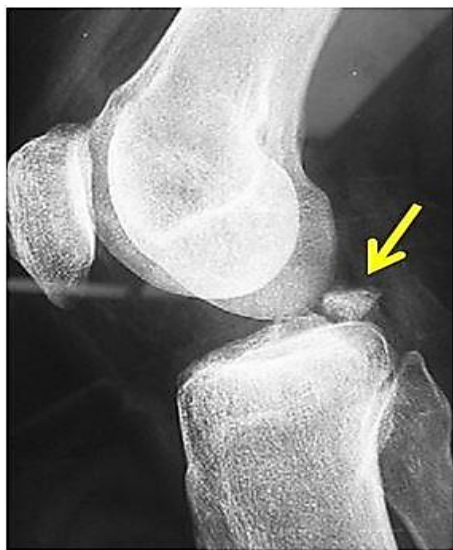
Lateral X-ray showing displaced posterior cruciate ligament (PCL) tibial bony avulsion fracture (yellow arrow)
